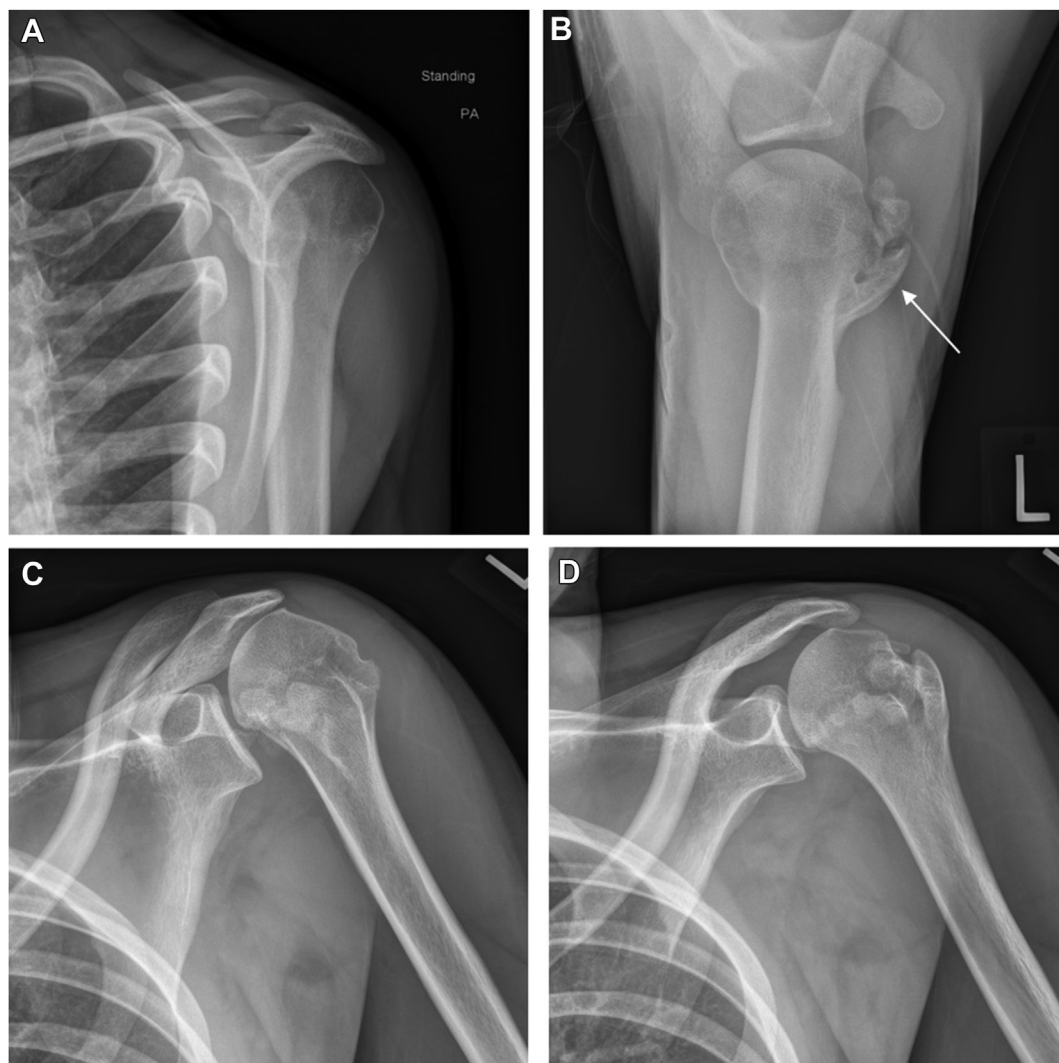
Preoperative plain film radiographs of the left shoulder. (A) Scapular Y view shows a 75% posteriorly subluxated humeral head. (B) Axillary view showing fragmented greater tuberosity malunion healed anterior to the lesser tuberosity (arrow). (C) Anteroposterior view showing significant humeral head superiorization and previous greater tuberosity fracture and malunion. (D) Grashey view redemonstrating humeral head superiorization and greater tuberosity fracture malunion.
